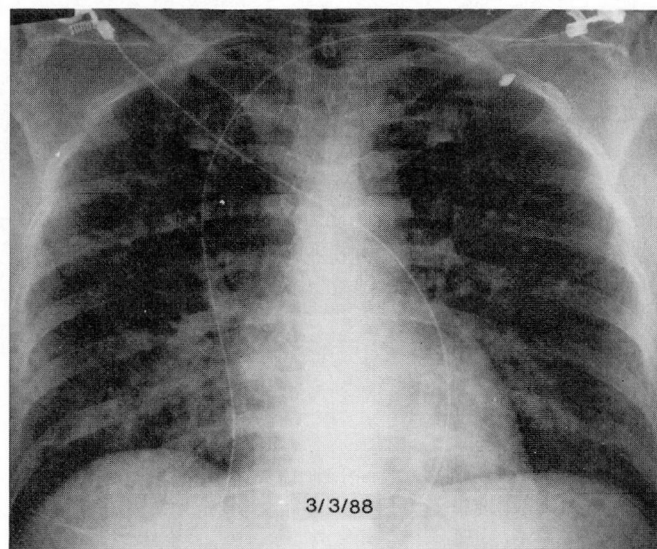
Chest radiograph at admission, demonstrating vascular congestion and bilateral perihilar infiltrates.
